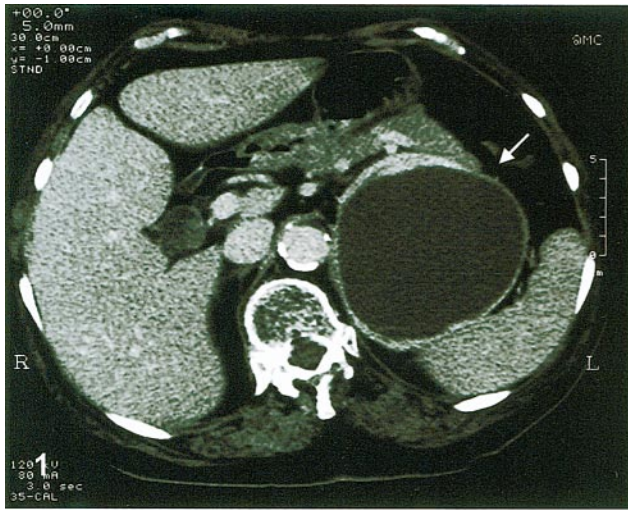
Computed tomographic scan of the upper abdomen shows a well-defined mass (arrow) that compresses the pancreas tail and spleen.
